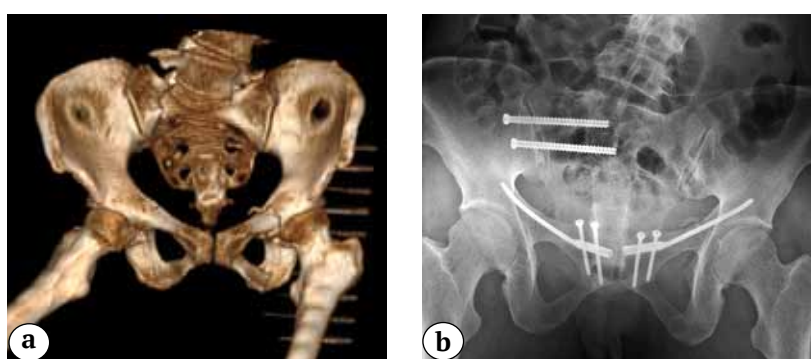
Osteosynthesis of pubic rami fractures using the interlocking nailing technique: pelvic fracture AO/OTA 61-B, pubic bone fractures (Nakatani III – right, Nakatani II – left) (a); final X-ray image after fixation of the pubic rami fractures with the interlocking nails and fixation of the sacrum with two cannulated screws (b)
